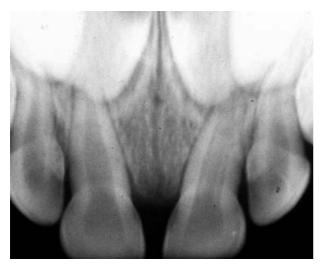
Radiograph showing two radio opaque strips in the pulp canal of the maxillary left central primary incisor indicating tube-like mineralization of the pulp.
